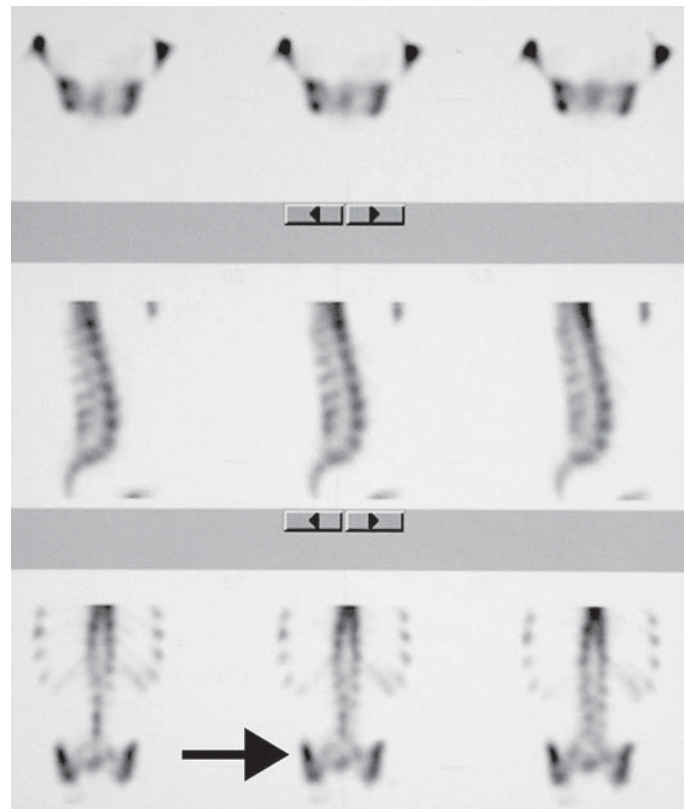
Normal bone SPECT. The sacral promontory is located between the right (arrow) and left sacroiliac joints and is prominently seen on the coronal images but shows normal intensity on the sagittal views (middle row).
